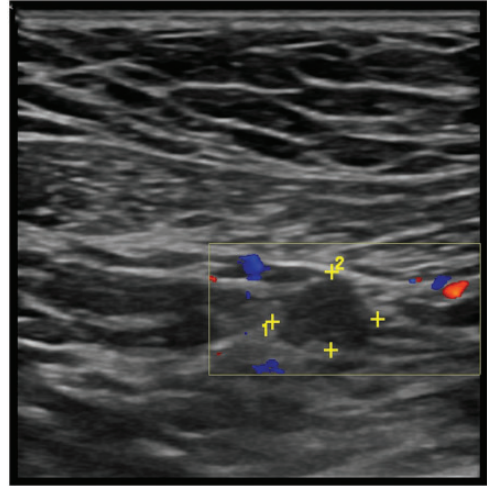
Ultrasound image of the tumor.
